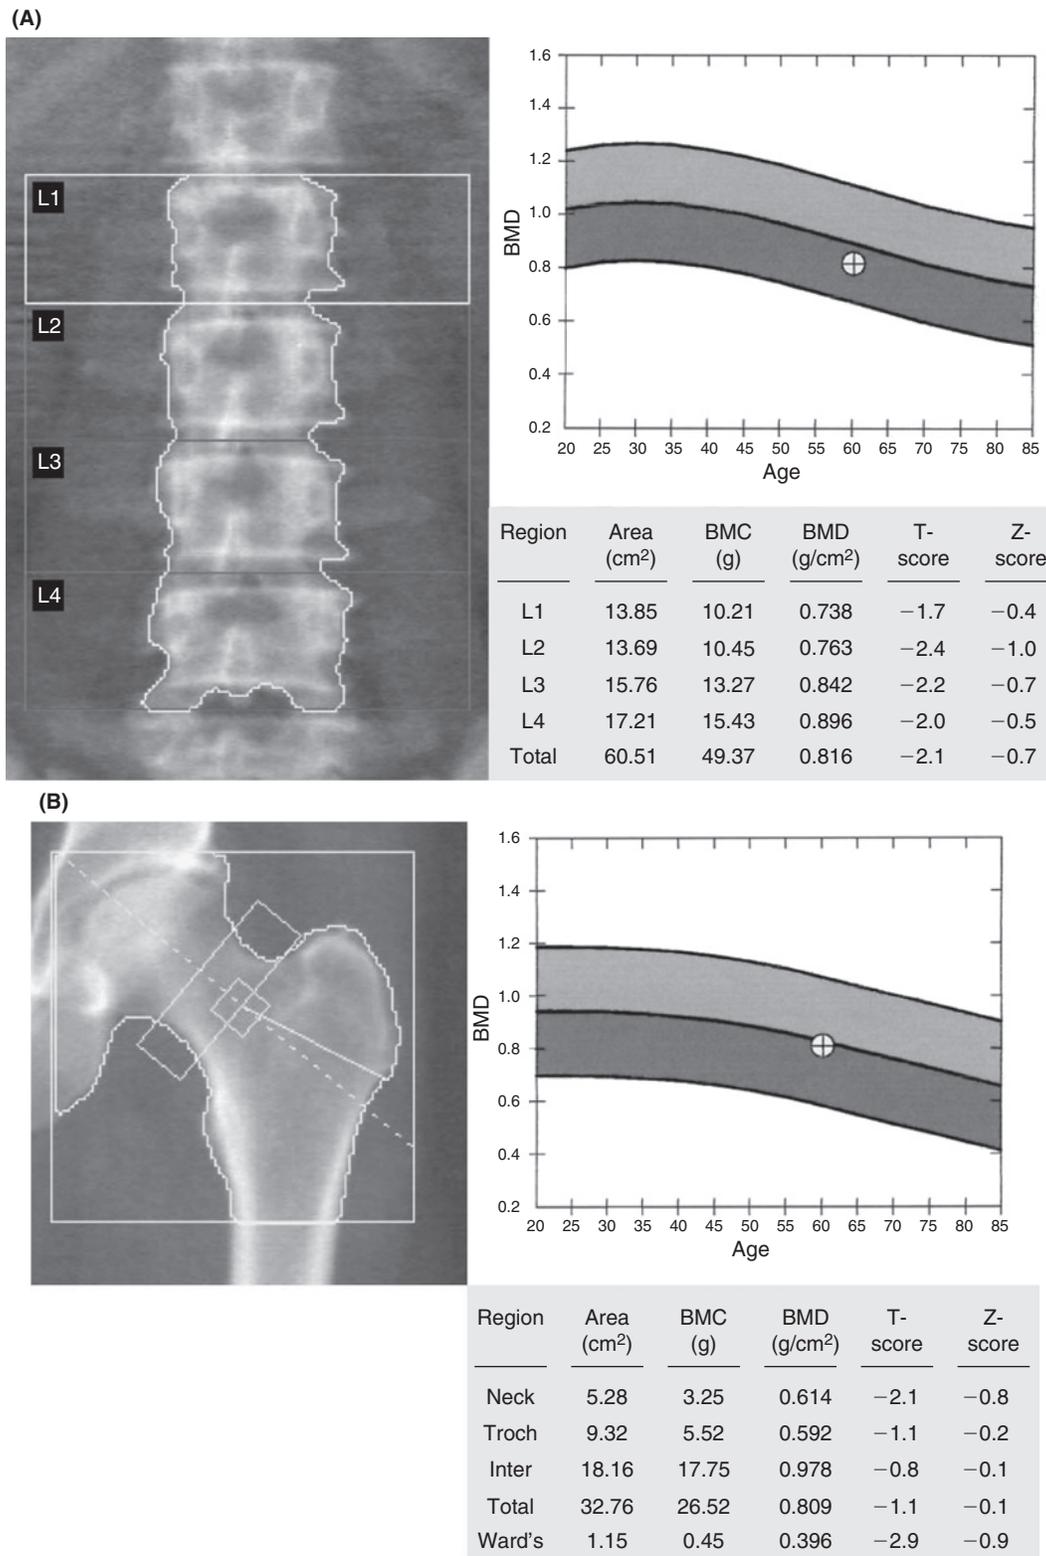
(A) Scan printout of a spine dual-energy x-ray absorptiometry (DXA) examination. The printout shows: (left) scan image of the lumbar spine; (top right) patient's age and bone mineral density (BMD) plotted with respect to the manufacturer's reference range; (bottom right) BMD figures for individual vertebrae and total spine (L1 – L4), together with the interpretation in terms of *T* scores and *Z* scores. (B) Scan printout of a hip DXA examination. The printout shows: (left) scan image of the hip; (top right) patient's age and total hip BMD plotted with respect to the National Health and Nutrition Examination Survey (NHANES III) reference range (Looker *et al.*, 1998); (bottom right) BMD figures for five different regions of interest in the hip (femoral neck, greater trochanter, intertrochanteric, total hip, and Ward's triangle), together with the interpretation in terms of *T* scores and *Z* scores by using the NHANES III reference range.
